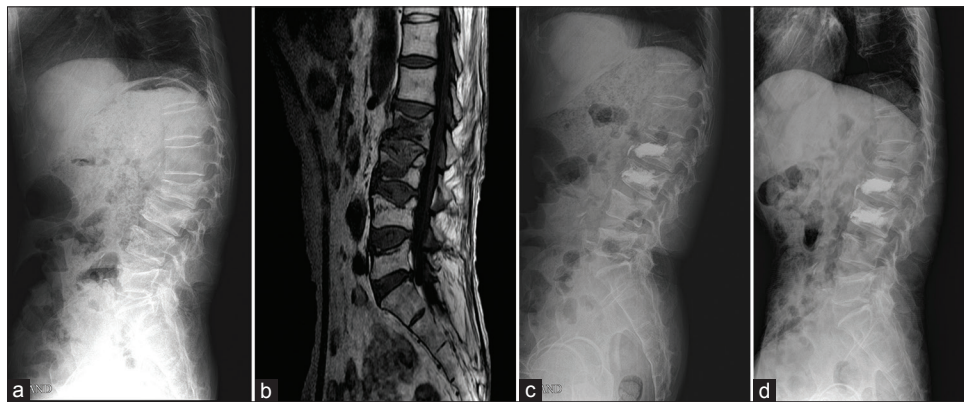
L2, L3 osteoporotic vertebral compression fractures in a patient with rheumatoid arthritis (case number 18). (a) Preoperative radiograph. (b) Preoperative magnetic resonance image. (c) Postoperative radiograph showing cement filling without leakage. (d) Adjacent segment fracture at L1 after 2 postoperative months
